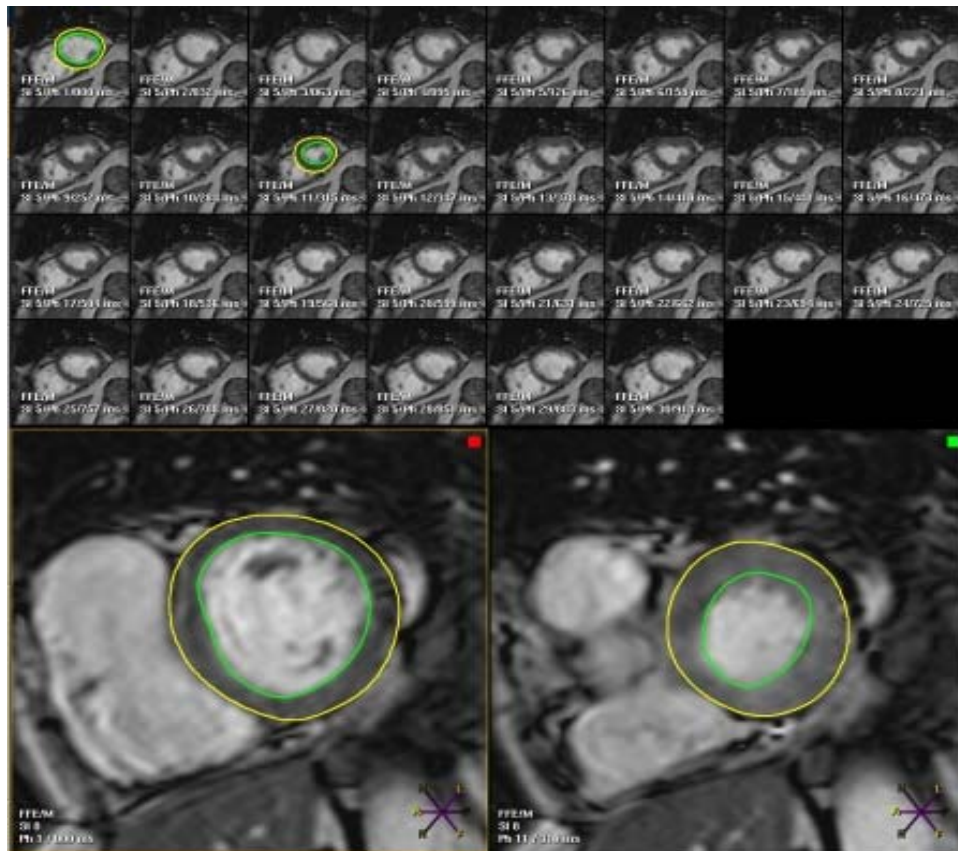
Functional analysis of short axis cine MRI. End diastolic (ED) and end systolic (ES) time frames are defined and then the endo and epicardial borders are manually drawn for each slice<sup>19</sup>
